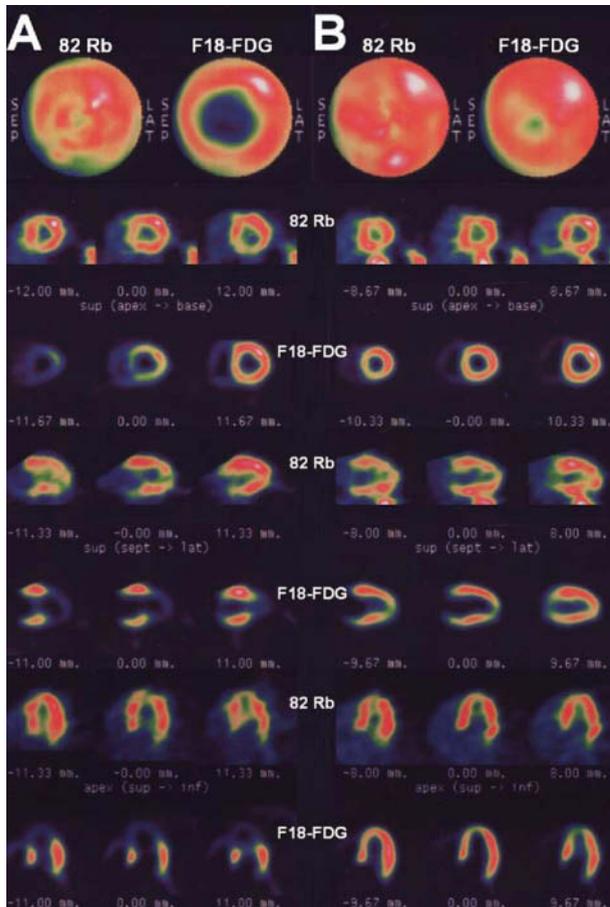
A, Myocardial PET images on hospital day 6 showing moderate perfusion defect involving distal anterior and apical wall. Metabolic images revealed severely reduced F-18 FDG uptake in a large area of the mid to distal anterior, anteroapical, apical, and inferoapical walls. Polar map images (top row) demonstrated a large area of metabolic defect out of proportion to perfusion. B, Repeat PET images 3 months later showing marked improvement of myocardial F-18 FDG uptake in the anteroapical and inferoapical walls.
